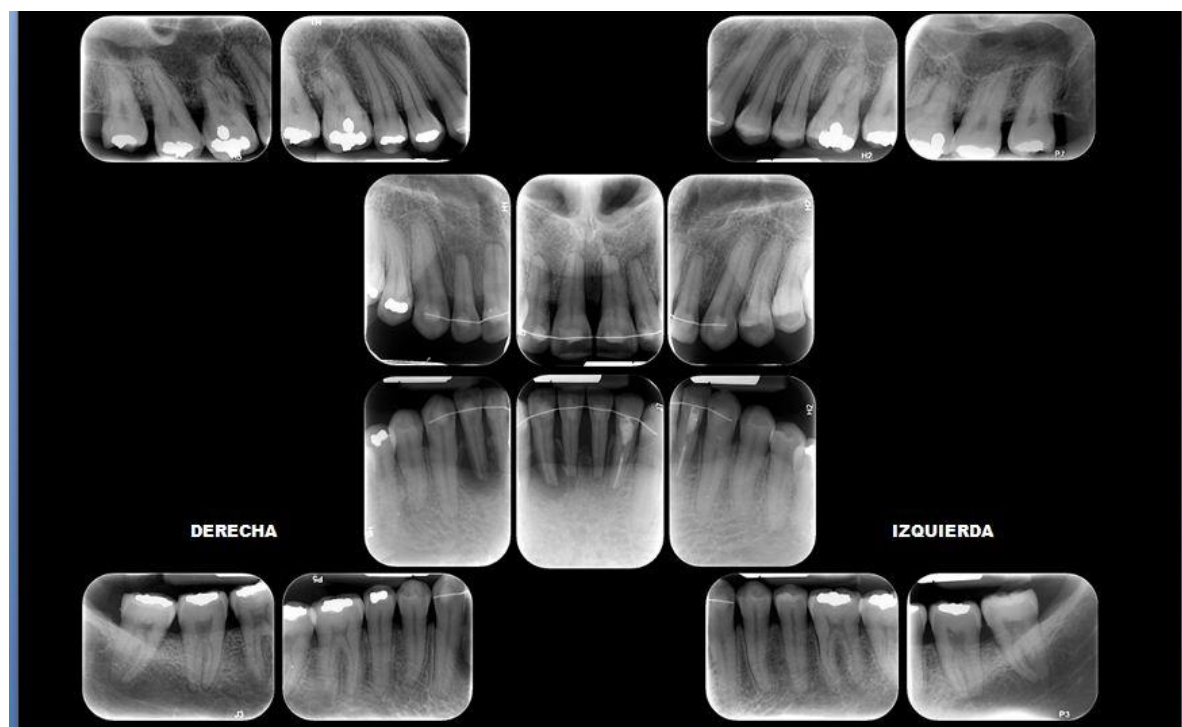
Complete post-treatment periapical set.
